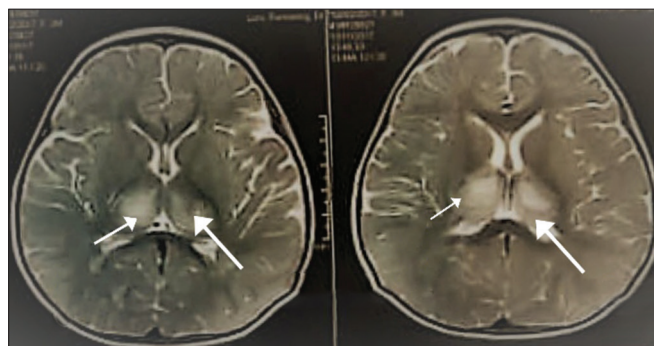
MRI Brain (T2W Axial image) showed bilateral symmetrical signals with enlargement of thalami
